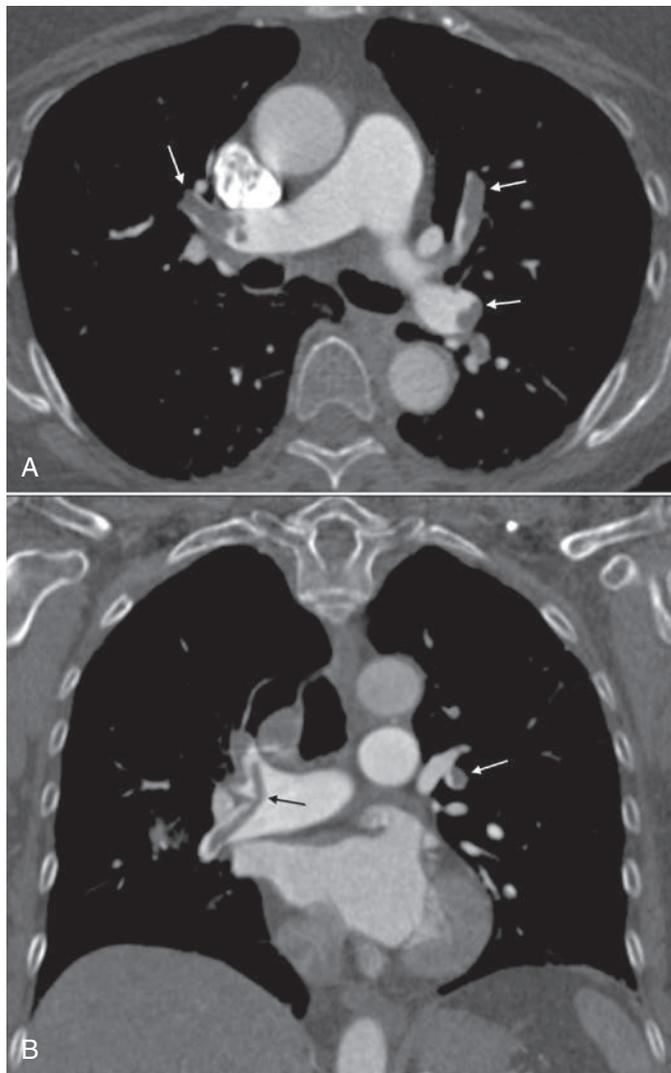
Computed tomography angiogram of a patient with bilateral acute pulmonary emboli. A, The pulmonary emboli are seen as the dark filling defects (arrows) outlined by the white contrast-enhanced blood vessels (arrows). Coronally reformatted image (B) is helpful to visualize clot entering both the right upper and right lower lobar pulmonary arteries (arrows).
